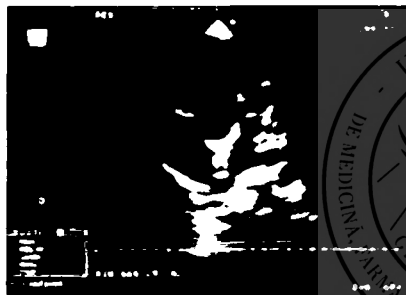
Echocardiographic short axis scan in a same patient with DORV.
